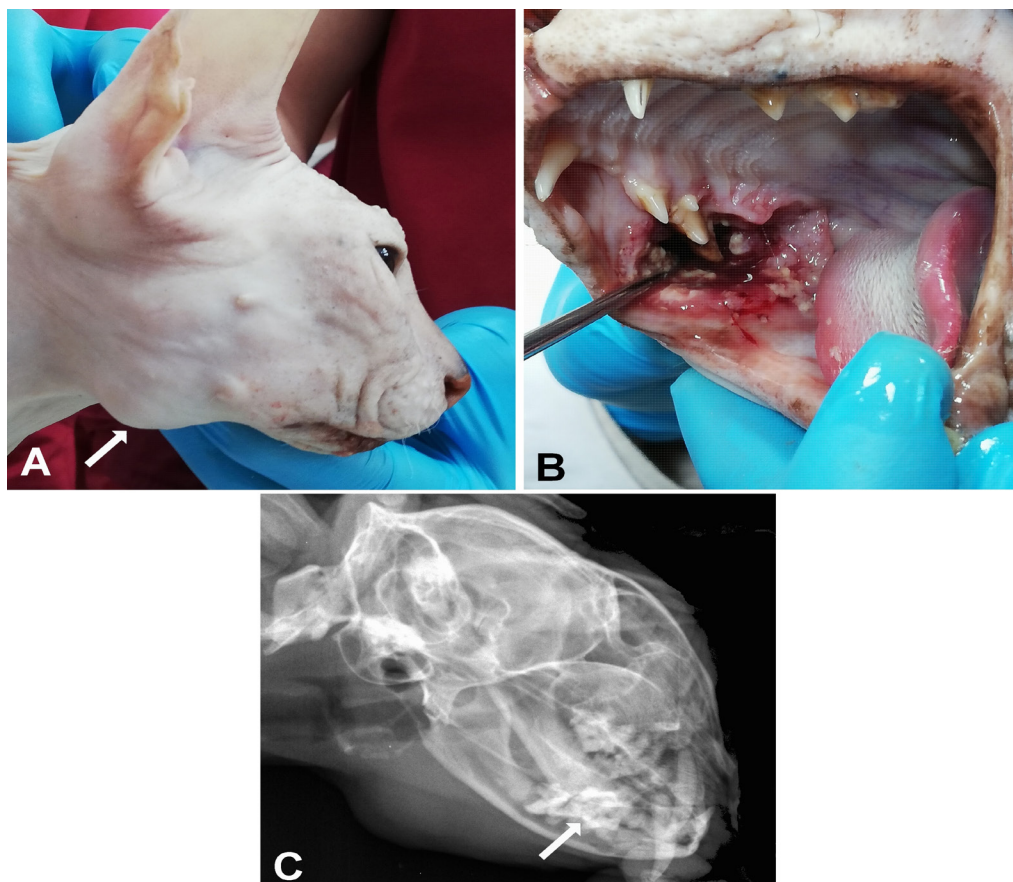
A- Enlarged lymph node (arrow) on the right mandibular region, B- Oral squamous cell carcinoma, necrotic-ulcerated appearance on right mandible and buccal mucosa, C- In the radiographic image, irregular appearance of molar teeth (arrow) in the mandibular region on the right side.
